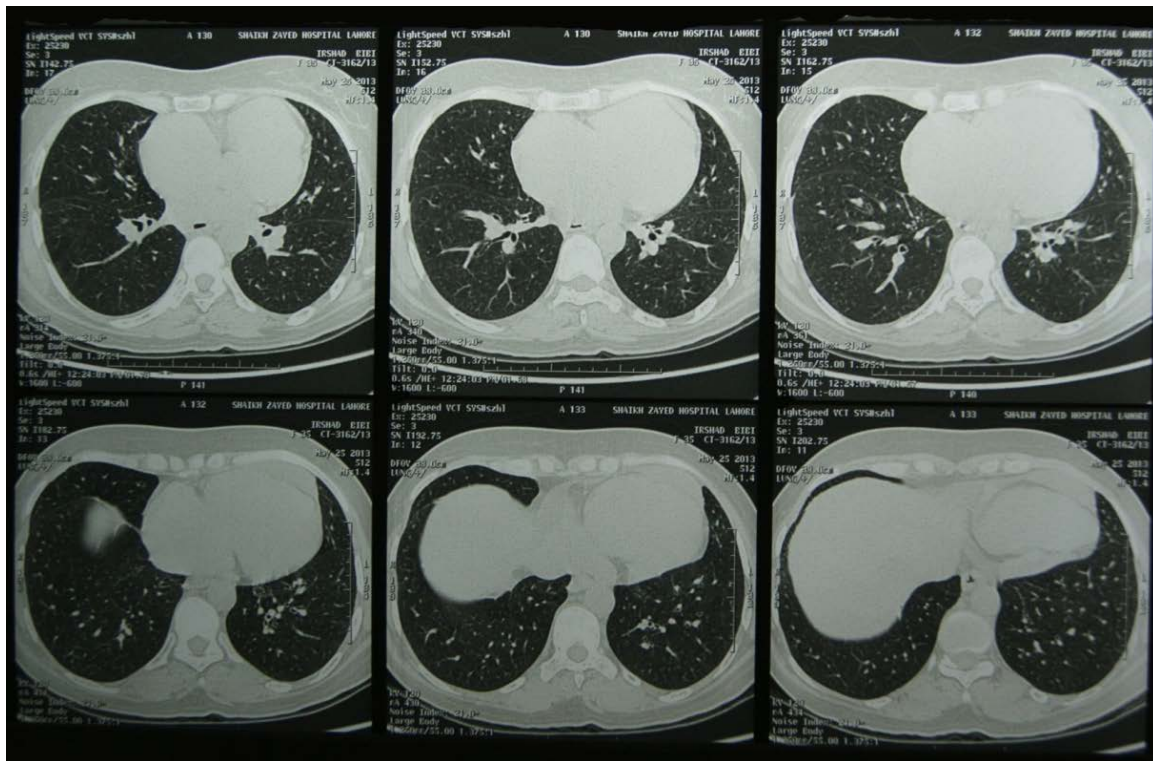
HRCT chest showing cardiomegaly with normal airways and lung parenchyma.
